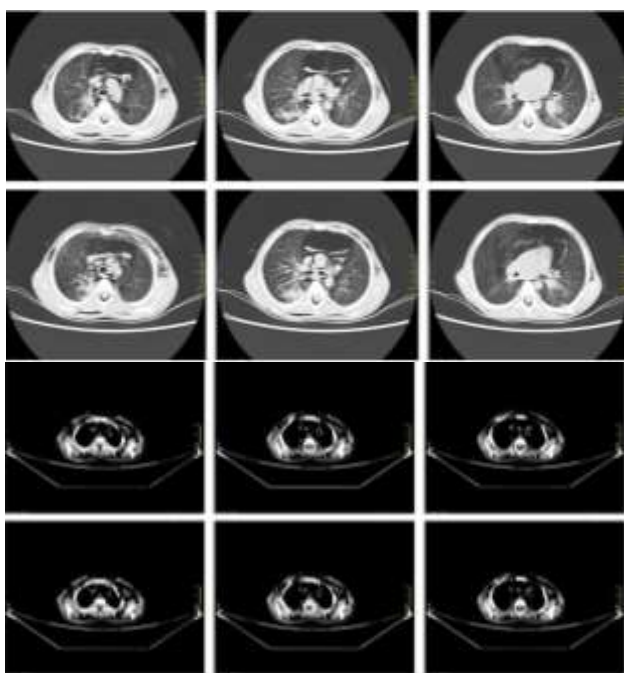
CT chest showing air in mediastinum and subcutaneous plane.
